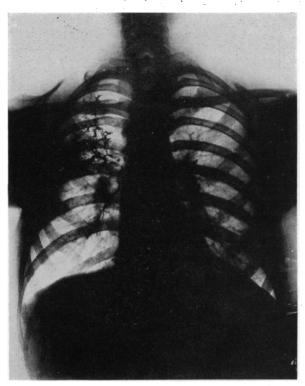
Case I. X-ray following injection of lipiodol into axillary sinus showing the presence of a bronchial communication.
